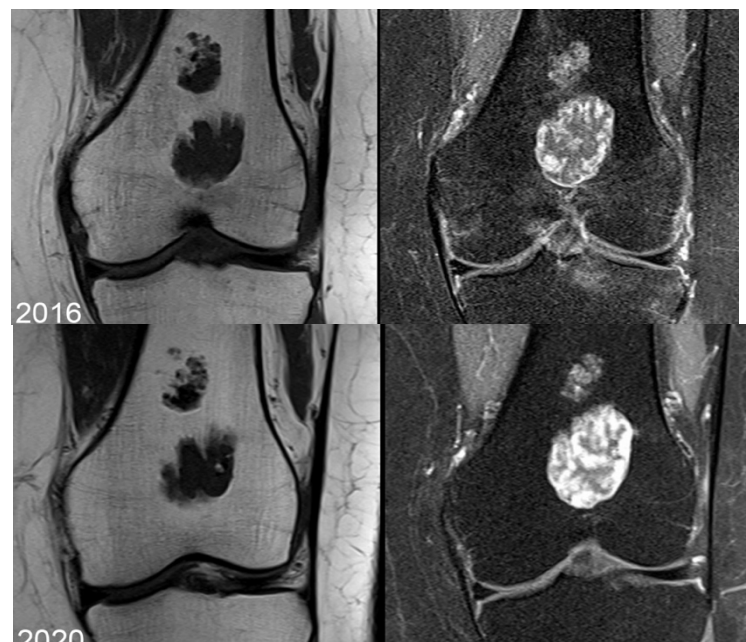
Female, 50 years: Enchondroma. Knee MRI for evaluation after contusion of the knee joint. The presentation of two separate lesions is unusual, but the images are typical for a chondroid matrix with inhomogenous contrast enhancement in the T1 weighted fat saturated images. No increase in size over the 4.5 years follow-up (top 2016, bottom 2020).
